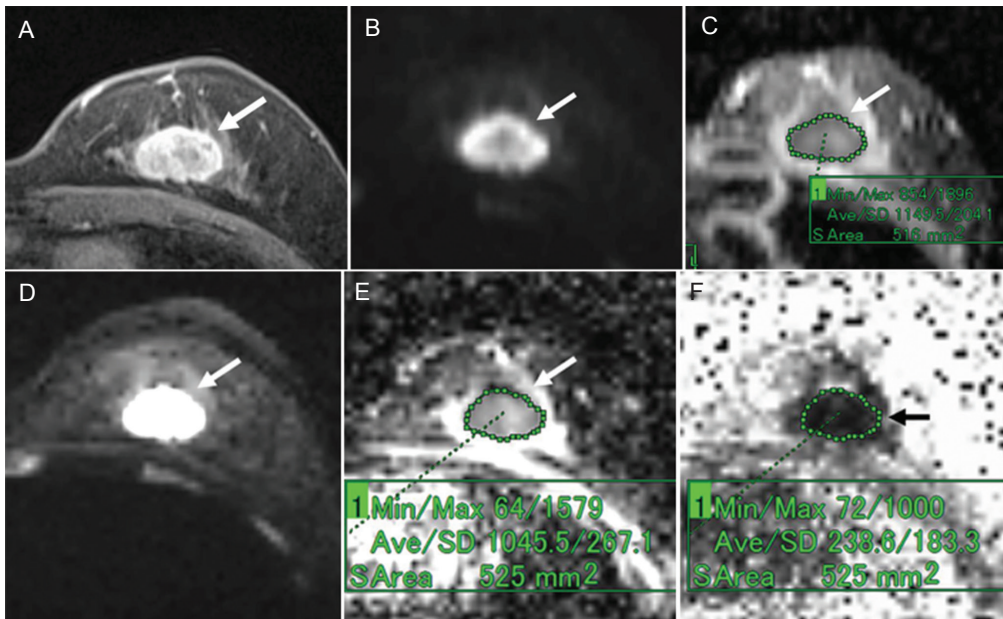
A 59-year-old woman with invasive ductal carcinoma (triple negative cancer). (A) Post-contrast, fat-suppressed, axial T₁-weighted image. (B) DWI based on ss-EPI. (C) ADC map of panel B. (D) DTI based on rs-EPI. (E) ADC map of panel D. (F) FA map of panel D. Post-contrast, fat-suppressed, axial T₁-weighted image shows an oval-shaped mass with a slightly irregular margin and rim enhancement (A). The mass shows high signal intensity on both the DWI based on ss-EPI (B) and the DTI based on rs-EPI (D). On the ADC map of the DWI image, the ADC of the mass was 1.15 (C). On the ADC map of the DTI image, the ADC of the mass was 1.05 (E). On the FA map, the FA value of the mass was 0.24 (F).
